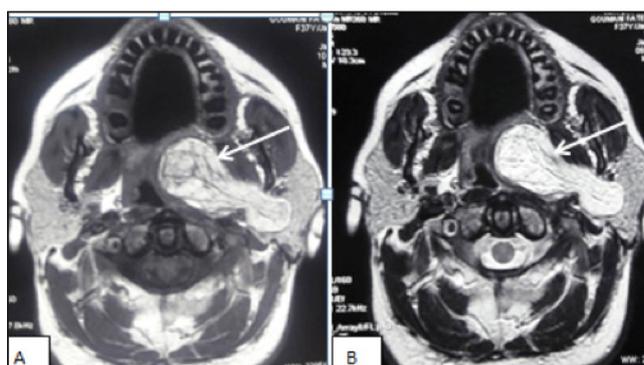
MRI of the neck axial view A: T1 weighted signal and B: T2 weighted sequences showing a mass with high signal intensity
